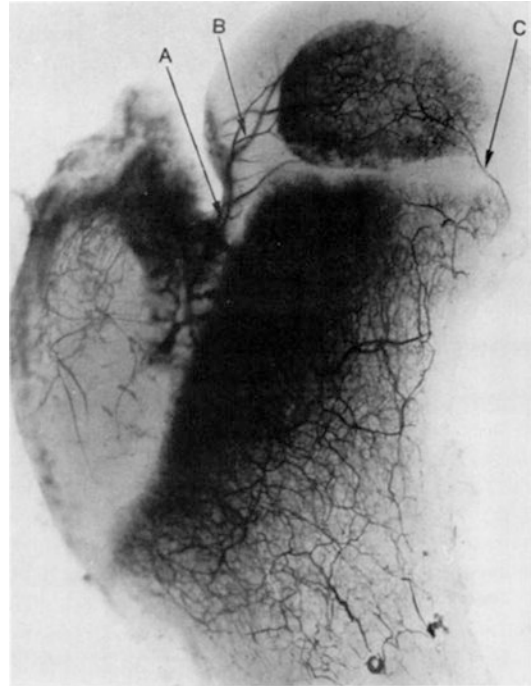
The lateral epiphyseal artery is labeled *B* in this radiograph. Reprinted with permission from *Journal of Bone and Joint Surgery American*, 1976, 58, The arterial supply of the developing proximal end of the human femur, Chung, 961–970
